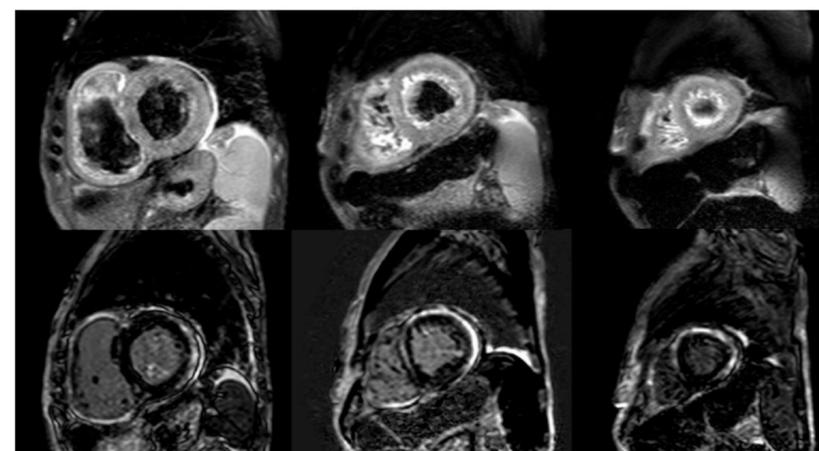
Cardiac MRI - T2 flair with diffuse myocardial hyperintensity (top row) with corresponding late gadolinium subepicardial enhancement with heterogenous enhancement on late Gadolinium imaging (LGE) (bottom row)
